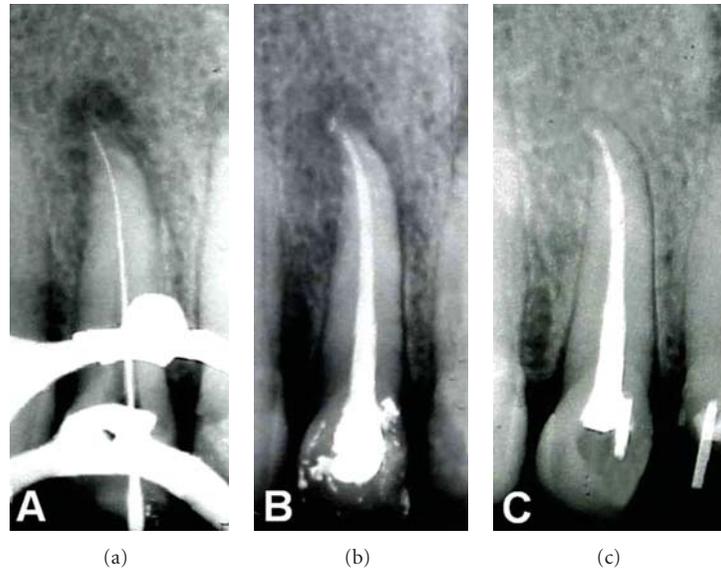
(a) Preoperative radiograph of a maxillary left lateral incisor presenting with a periapical radiolucency. (b) Immediate postoperative radiograph. (c) After 10 years, the recall radiograph revealed that the periapical structures had returned to normal.
